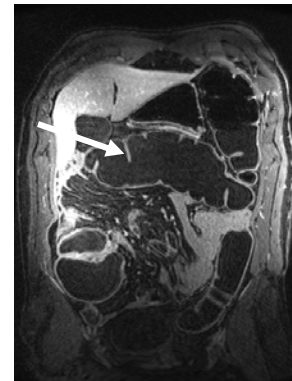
2D-accelerated post-contrast 3D T1-weighted MRC from the same patient. Note the improved visualization and reduced blurring of the haustral fold (arrow) compared to Fig. 2. All imaging parameters were the same except breathhold time.
